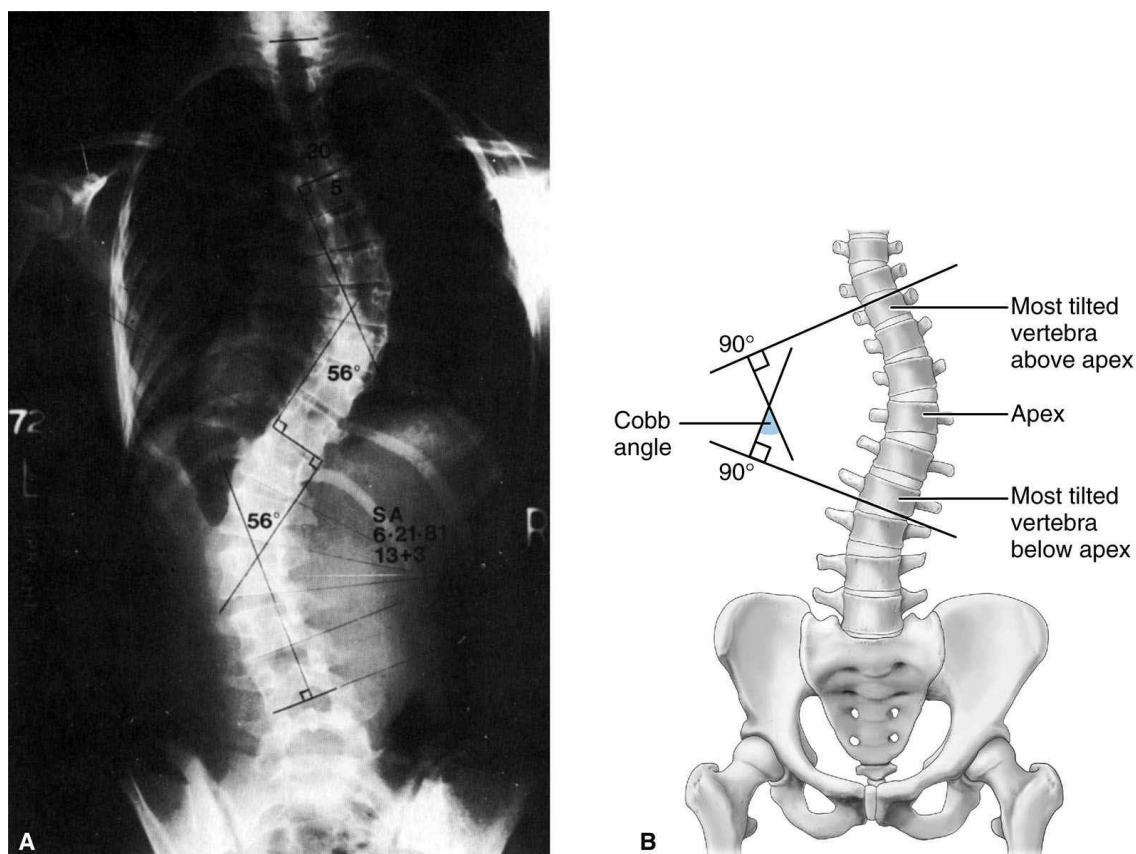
Cobb angle measurement noted on radiograph (A) and figure (B).
